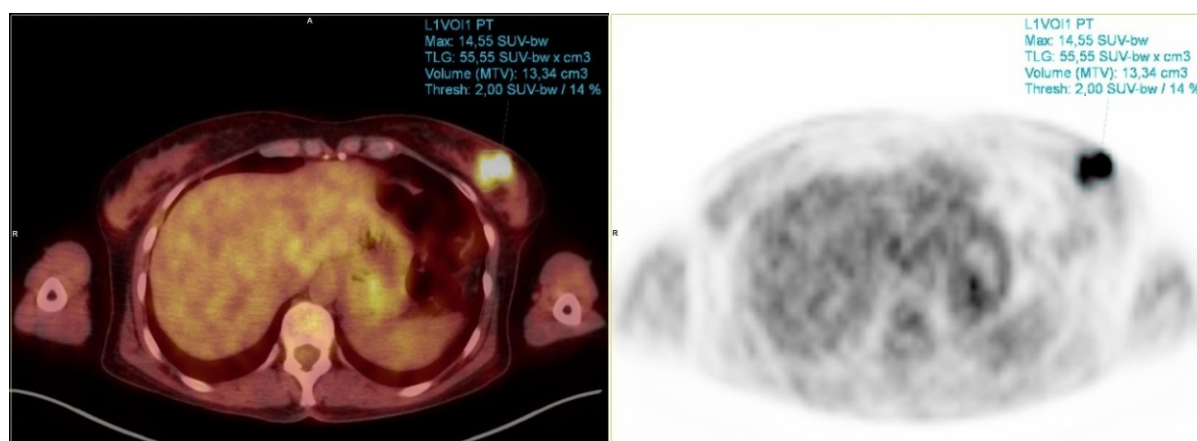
Positron emission tomography/CT fusion and PET-only images showing SUVmax, MTV 2.0 and TLG measurements in ER-positive, PR-positive, and HER2-positive breast cancer.
